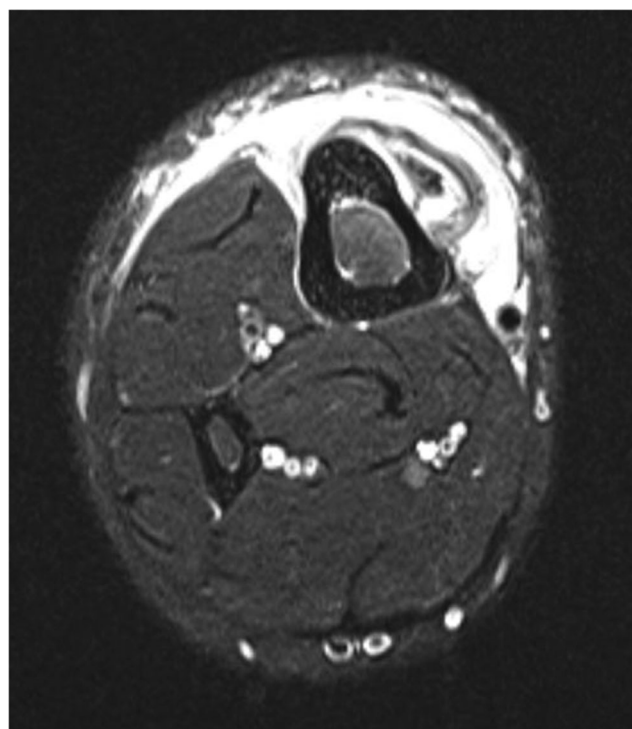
Axial T2-weighted, fat-suppressed MRI image through the area of maximal swelling of the right leg
